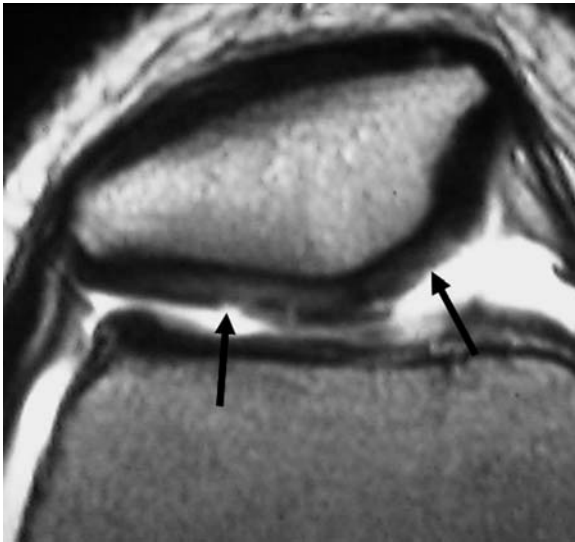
Chondromalacia. Axial T2 fat suppressed MR image showing small defects in the articular cartilage (arrows)
